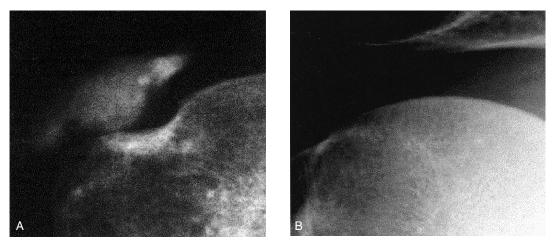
(A) Anteroposterior radiograph showing a Gärtner II deposit (inhomogenous structure with well defined border). (B) Anteroposterior radiograph showing a complete disintegration 12 months after shock wave application.
